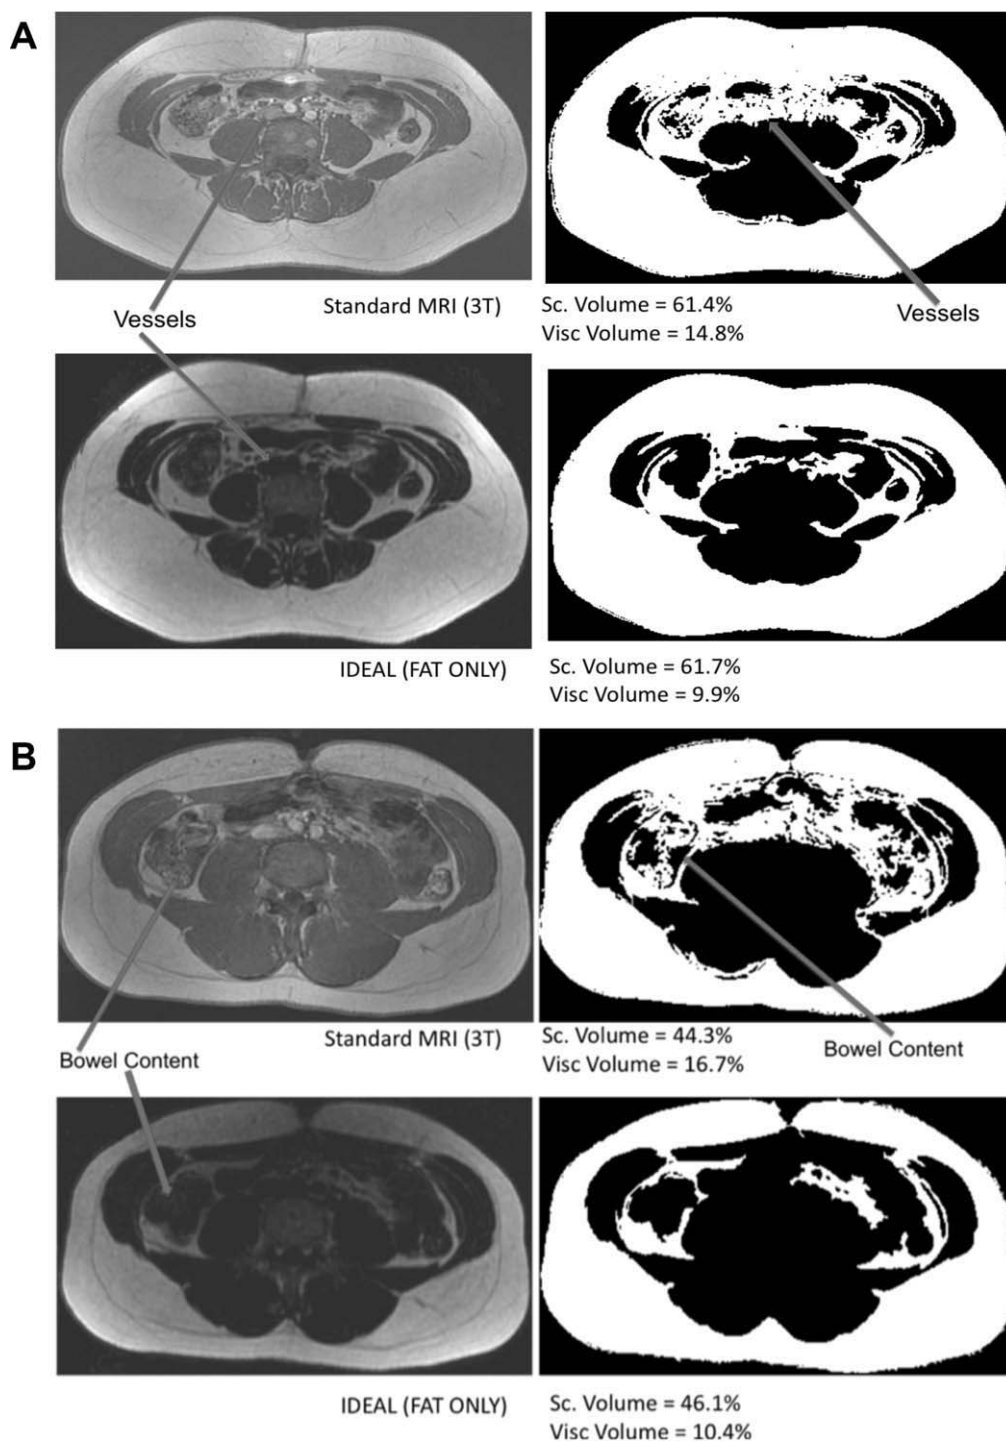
A: The lower value of visceral adipose tissue volume given by IDEAL relative to 3.0T SPGR imaging (9.9% versus 14.8%) reflects an improved ability to differentiate between true visceral adipose tissue and bright structures like blood vessels that could be mistaken for adipose tissue in the non-fat suppressed T1-weighted images as shown. B: The lower value of visceral adipose tissue volume given by IDEAL relative to 3T SPGR imaging (10.4% versus 16.7%) reflects an improved ability to differentiate between true visceral adipose tissue and bright structures like bowel content that could be mistaken for adipose tissue in the non-fat suppressed T1-weighted images as shown.
